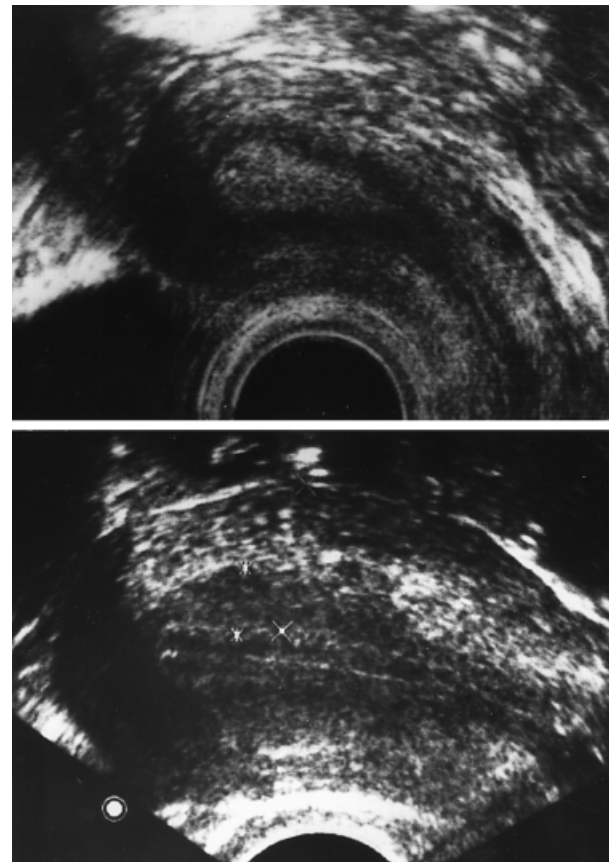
Vaginal sonography in a sagittal scan of the whole uterus of a woman without endometriosis (top). The subendometrial myometrium is visible as a halo immediately adjacent to the endometrium. The thickness of the halo comprises about one-quarter of the total thickness of the myometrium on the mid-corporal section of the uterus. In a woman with endometriosis (bottom) the halo is irregularly expanded and comprises about the half of the thickness of the endometrium.
